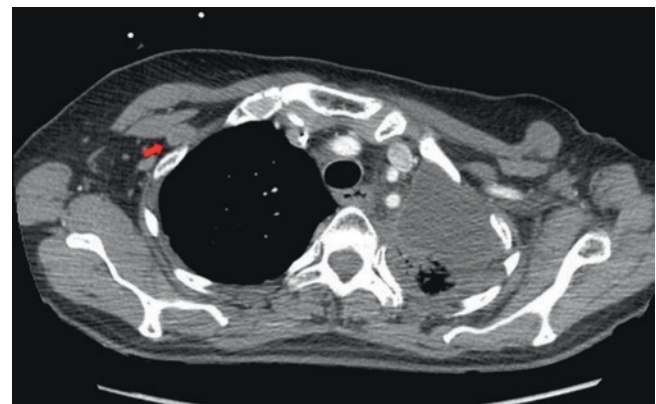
Patient with history of left mastectomy. CT axial plane shows an enlarged and round retropectoral lymph node, suggesting recurrence. Despite retropectoral involvement, the axillary lymph nodes were negative and asymptomatic
